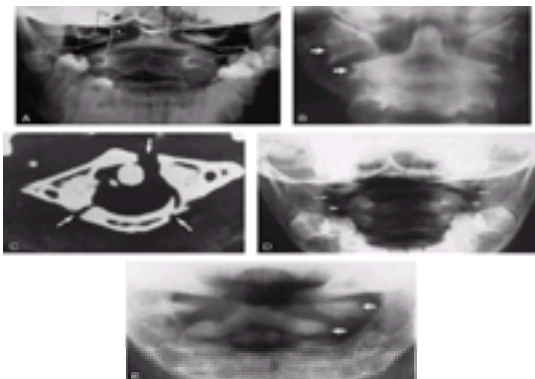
A. Normal anteroposterior (AP) (open-mouth, odontoid) view of C-1 and C-2. *C*₁, first cervical vertebra (lateral mass); *C*₂, second cervical vertebra; *T*, central incisors overlying dens (*D*); A, normal relationship between lateral mass of C-1 and vertebral body of C-2. B. Jefferson fracture in AP view. Note lateral offset of C-1 on C-2. C. Jefferson fracture. Computed tomography coronal view. Note three distinct fractures and bursting nature of injury. D. Pseudo-Jefferson fracture of childhood in a 3-year-old child because of disparate growth of C-1 and C-2 and cartilage artifact. E. Pseudo-Jefferson fracture demonstrating marked offset of the lateral masses of C-1 on C-2. (B and C reprinted with permission from Swischuk L. *Emergency Radiology of the Acutely Ill or Injury Child*. 2nd ed. Baltimore: Williams & Wilkins, 1986:591; D reprinted with permission from Aslamy W, Danielson K, Hessel S, et al. A 3-year old boy with neck pain after motor-vehicle accident. *West Med J* 1991;155:301–302.)
